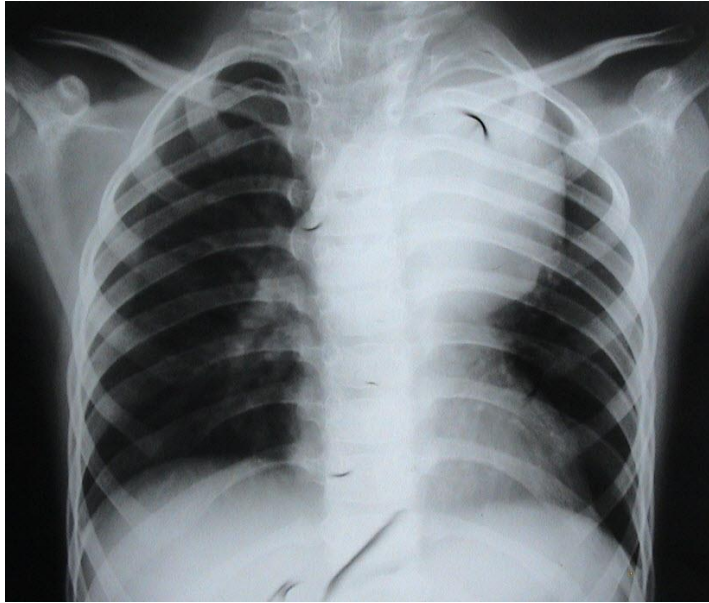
Chest x-ray shows a round opacity in the left mediastinum.
